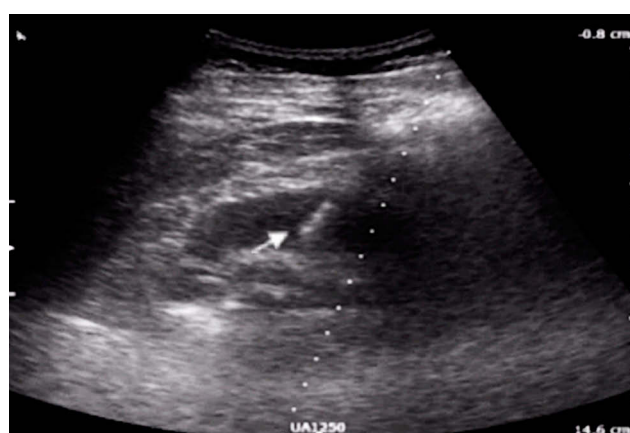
Ultrasound showed the tip of puncture needle (arrow) had reached the target calyx.
